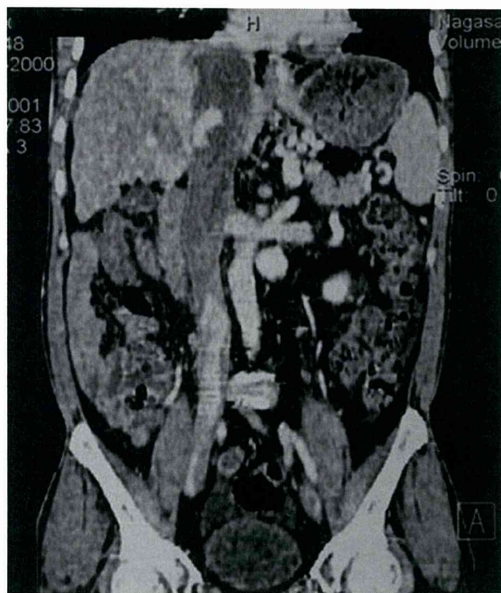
Coronal view of preoperative abdominal computed tomography (CT) showed thrombosis of the inferior vena cava (IVC) extending from the suprahepatic IVC to below the left renal vein, a cirrhotic liver, and collateral vessels
